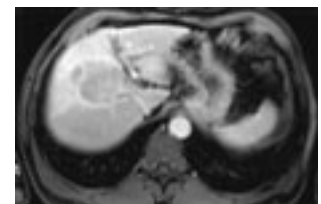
Contrast enhanced MRI before treatment with DEB TACE showing a solitary HCC in the right lobe
